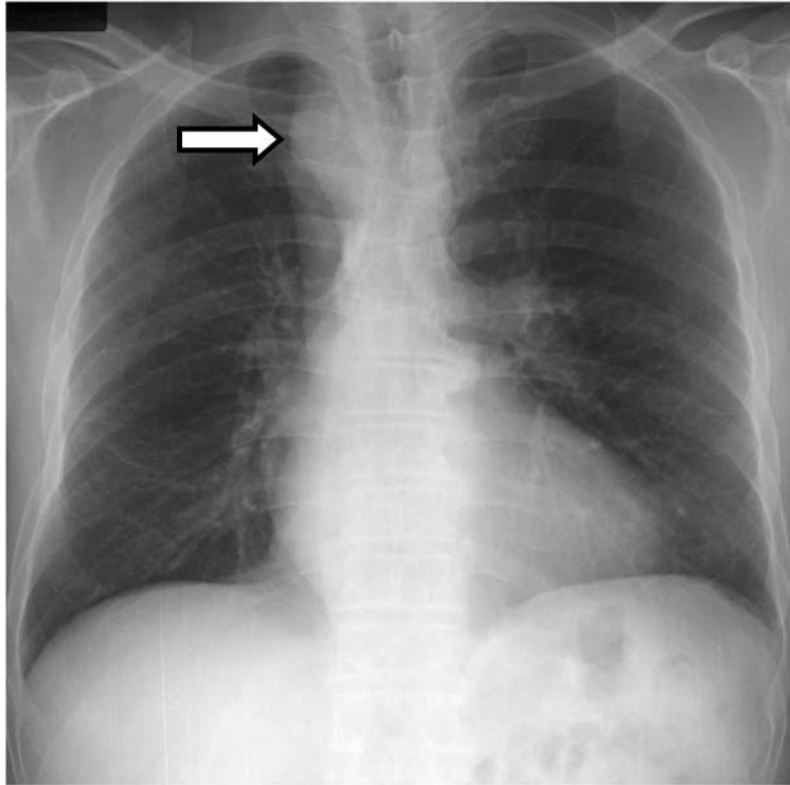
Chest X-ray. The aortic arch was located on the right side (⇨).
